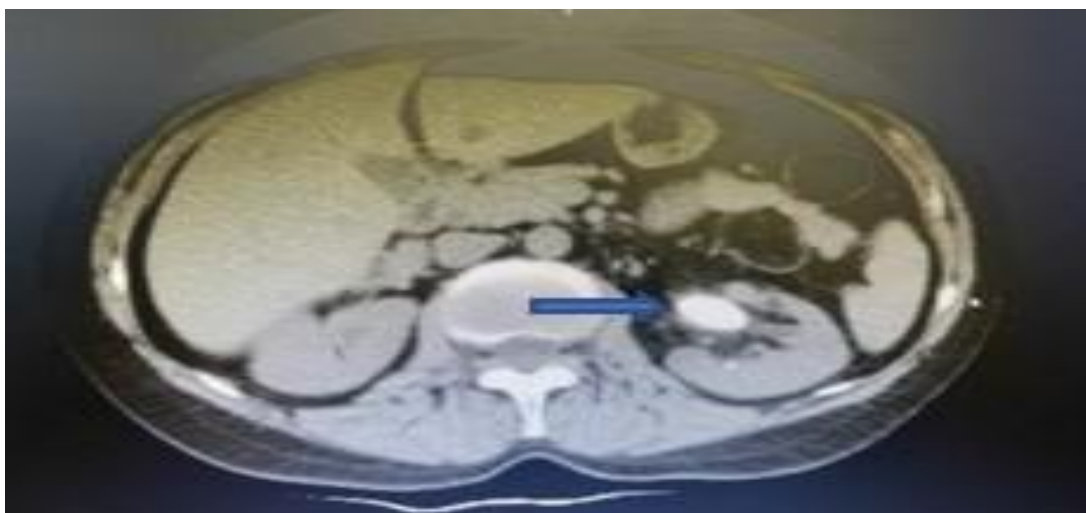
Stone in the renal pelvis, pre-operative CT image, (blue arrow)
